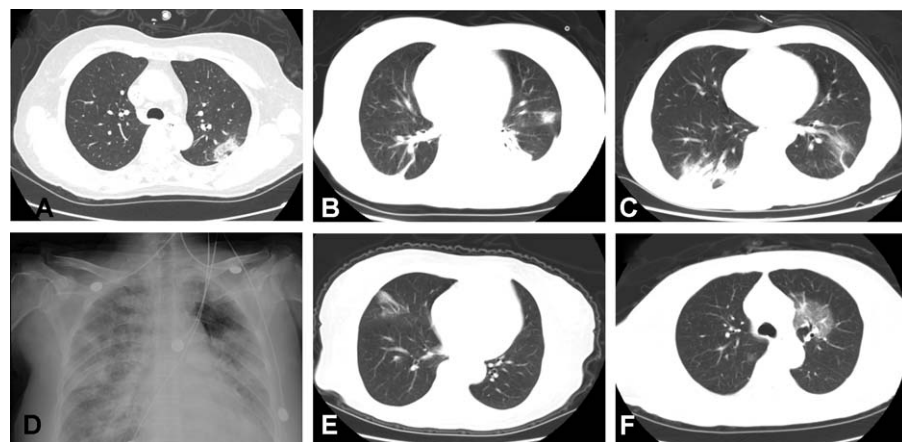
Postoperative chest radiological findings of the 6 gastrointestinal cancer patients with pre/asymptomatic COVID-19. Chest computed tomography images showed typical findings with ground-glass opacity or consolidation: A to C, E, and F, patient 1 to 3, 5, and 6; chest radiograph of 1 severe patient showed bilateral stable streaky opacities: D, patient 4.
